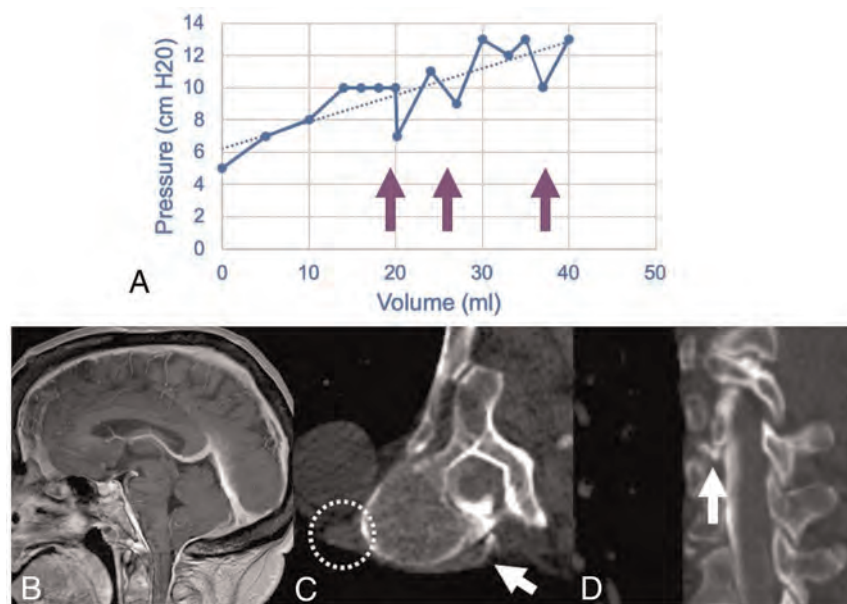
A craniospinal compliance curve in a 70-year-old woman with confirmed CVF (A) shows high compliance (ie, smaller change in pressure per increase in volume) with multiple abrupt pressure drops (arrows) above 10 cm H₂O. Recent brain MR imaging shows characteristic features of SIH (B), including reduced mamillopontine distance, low cerebellar tonsils, and pachymeningeal enhancement. A right T7–8 CVF was identified on decubitus CT myelography (C and D). Hyperdensity of the paraspinal vein and azygous vein (dashed circle) aids in identification of the fistula (white arrows). The patient was treated with percutaneous fibrin glue injection.
